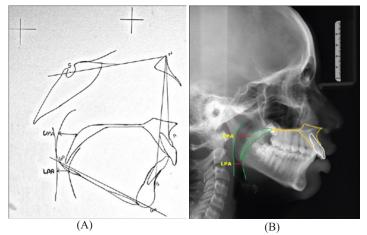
A, B. Cephalometric radiograph indicating the upper pharyngeal airway and lower pharyngeal dimensions for measuring the pharyngeal dimensions according to McNamara. (Prabhakaran Mani. J Pharm Bioallied Sci.2015).
